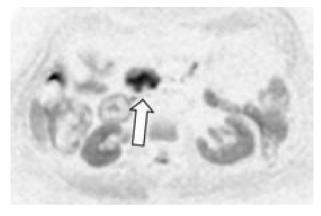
Axial DWI MRI shows a high signal in the pancreatic head that had a low ADC (not shown). This finding is compatible with a diagnosis of pancreatitis due to cancer (*arrow*) of the pancreas head
